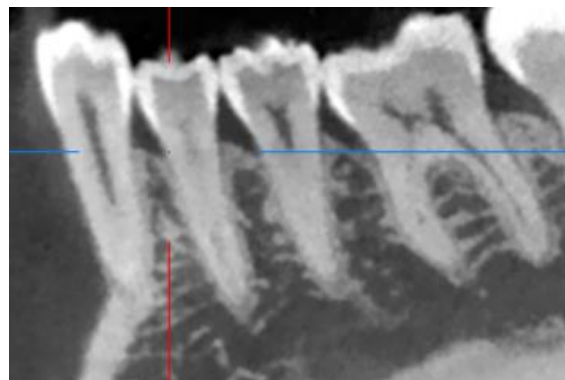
3D computed tomography in the area of 43, 46 teeth
